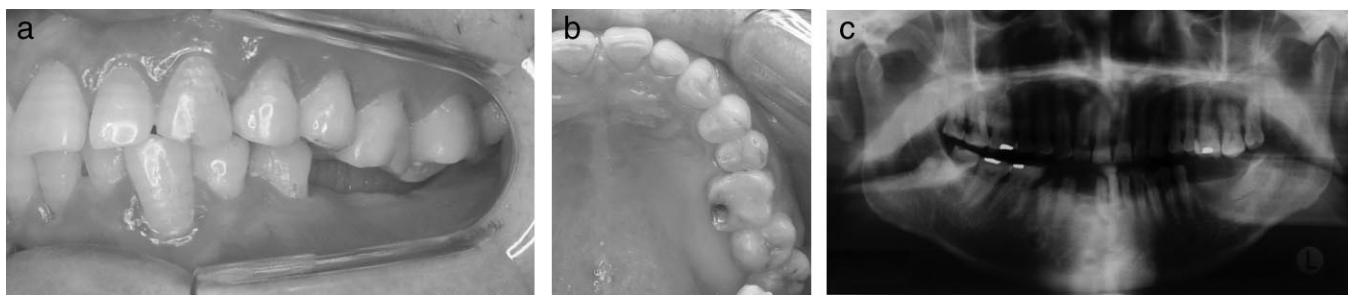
(a, b) Initial intraoral photograph. (c) Initial radiograph.
